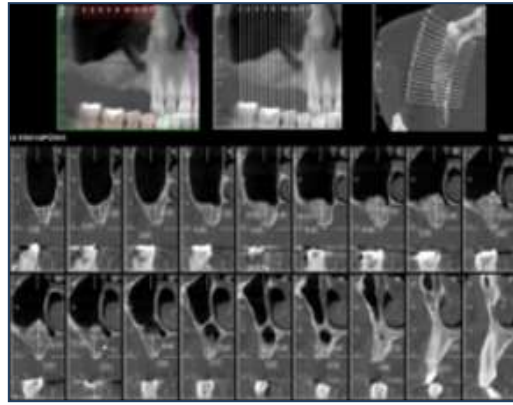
The newly formed bone 6 months after the surgery is obvious at the radiographs prior to the implant placement.
